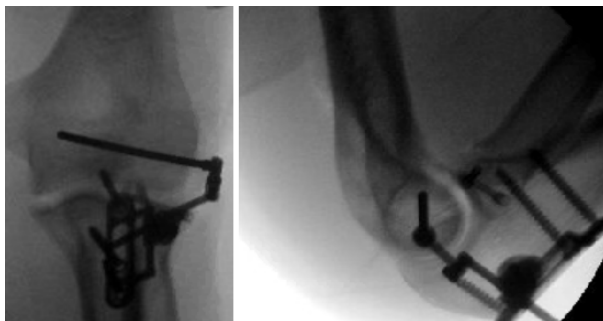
Case 1 pre-operative radiographs demonstrating elbow subluxation at four weeks following injury.
